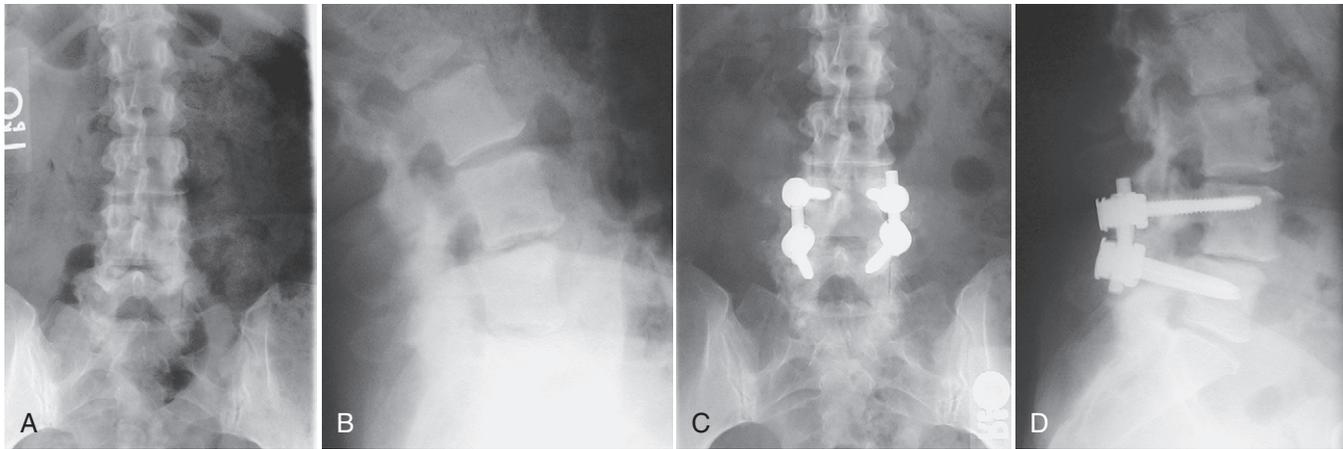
A, AP and, B, lateral lumbar spine radiographs demonstrating Grade 1 spondylolisthesis in a 47-year-old woman with disabling back and leg pain refractory to nonoperative treatment. C, D, Postoperative radiographs demonstrating stable fusion 1 year following posterior decompression and fusion with supplemental instrumentation. Note the robust fusion mass bridging transverse processes laterally. The patient is pain free and has returned to full level of activity including triathlons and skiing.
